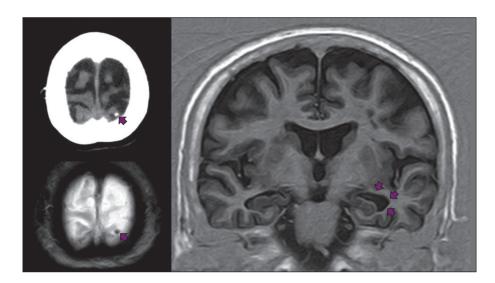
Unenhanced CT and gradient-echo (686/23) MRI (left panel) showing a single parenchymal brain calcification in the left occipital lobe (arrow), and T1-weighted inversion recovery MRI sequence (right panel) showing asymmetric hippocampal atrophy, more marked on the left (arrows).
